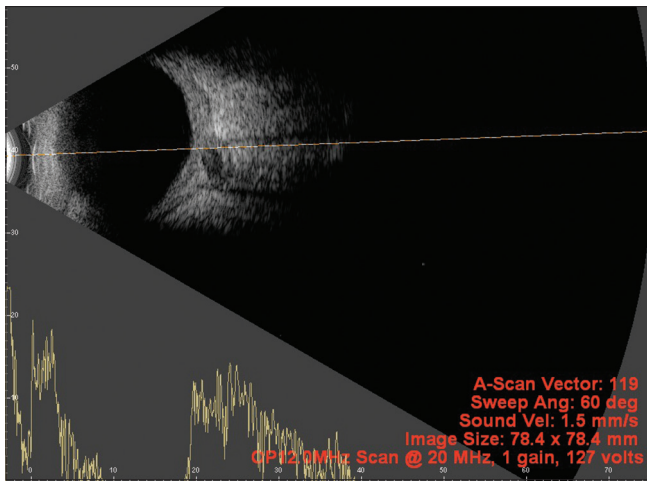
Ultrasound B-scan along with A-scan (below) of the patient acquired after using all standard work instructions as highlighted in the text
